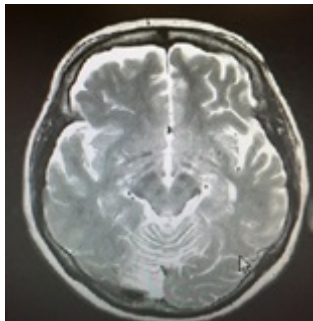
Slightly high signals in the basal cisternas with the thickening of dural surfaces on FLAIR images.
